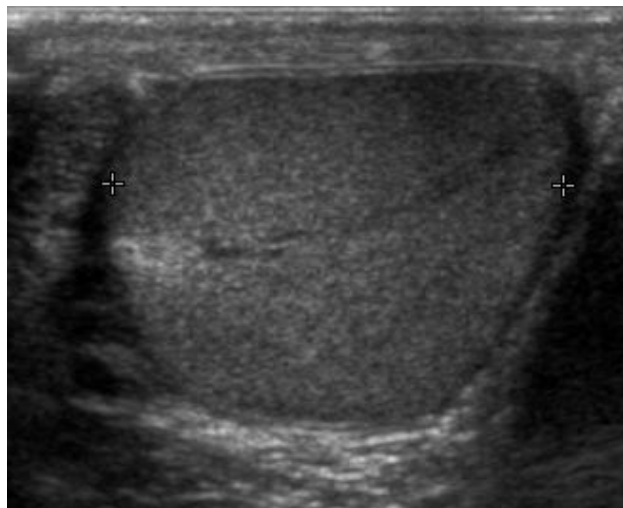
Sonography of a normal testis. The normal testis presents as a structure having homogeneous, medium level, granular echotexture. The mediastinum testis appears as the hyperechoic region located at the periphery of the testis as seen in this figure
